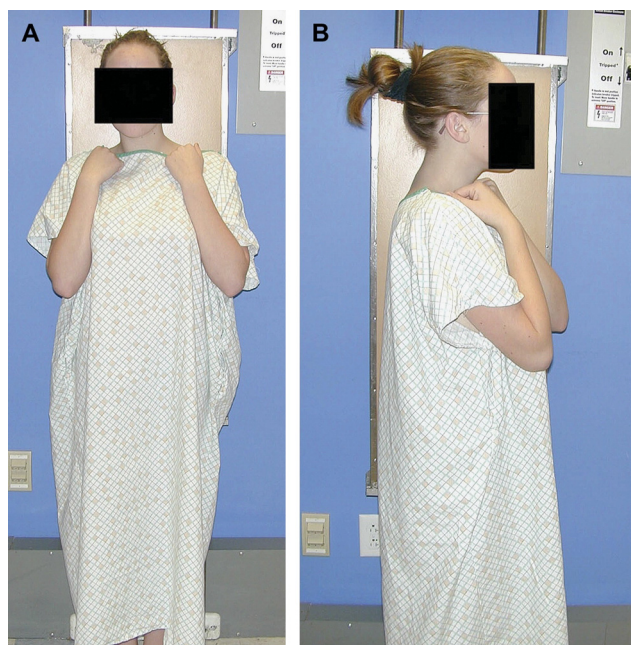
Full-length PA and lateral radiographs of the spine (A) The PA view was traditionally taken with 36-in film with the image intensifier at a distance of 72 in. (B) The lateral view is obtained in the same fashion, with the patient’s hands in the supraclavicular fossa.
